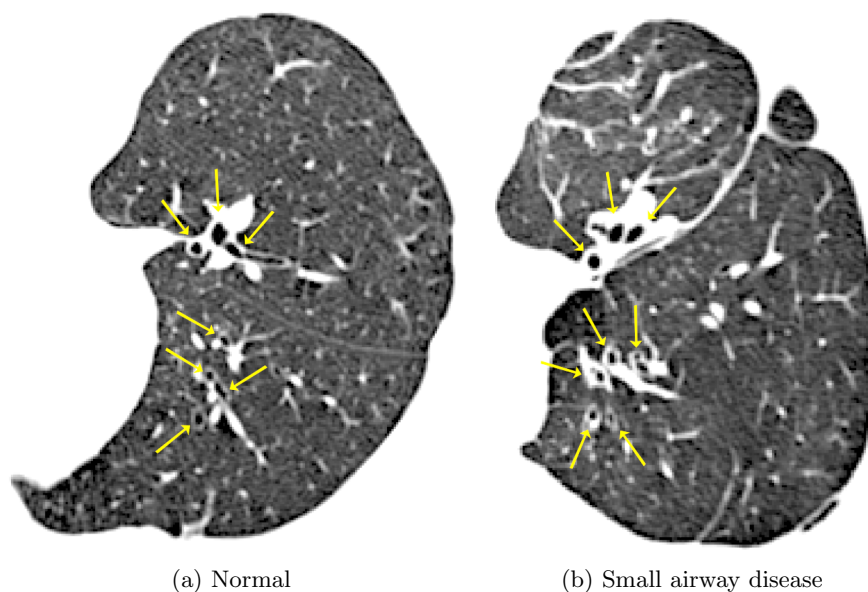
CT lung slice showing example of normal and thickened airway walls. Arrows point to examples of visible airways.
